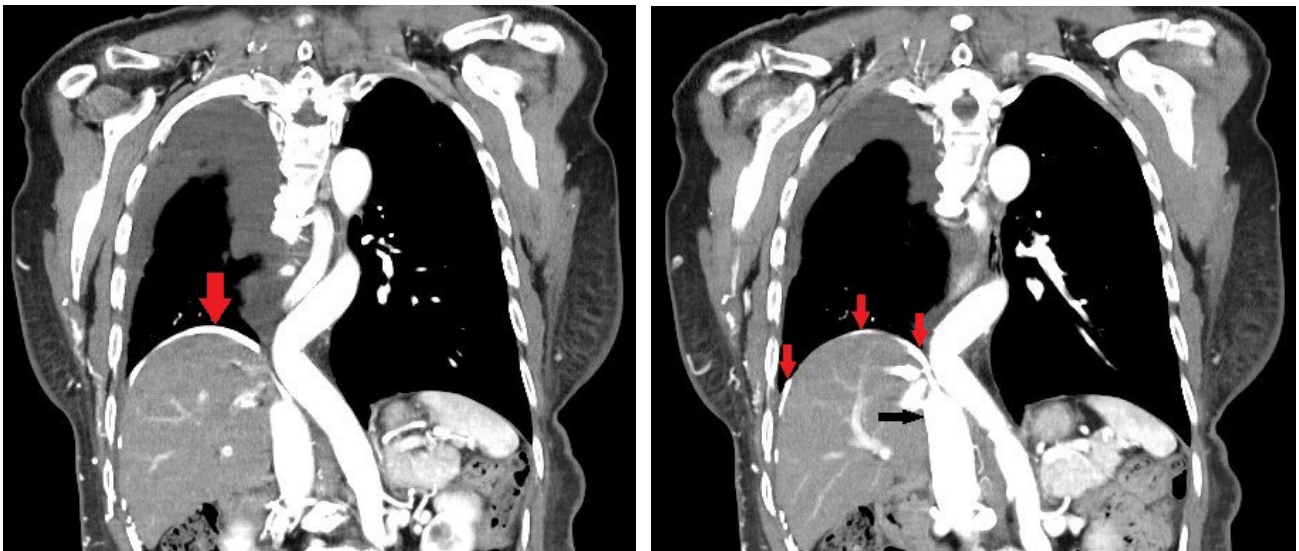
and 2B: Coronal view of the chest CT image showed right phrenic venous route (Red arrows) drained into the inferior vena cava (Black arrow).
